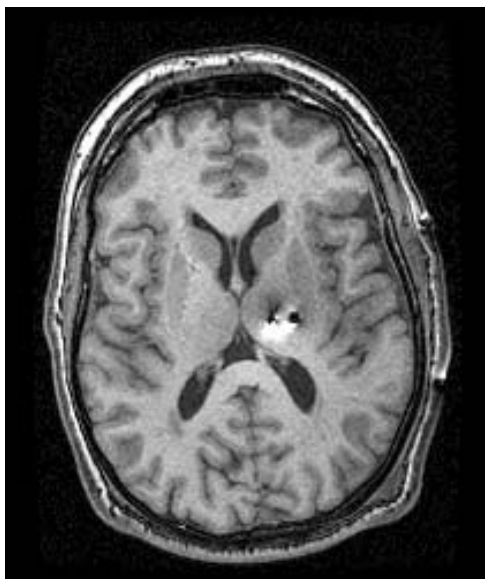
An axial MRI scan showing electrodes in the VPL (lateral) and PVG (medial) nuclei.
